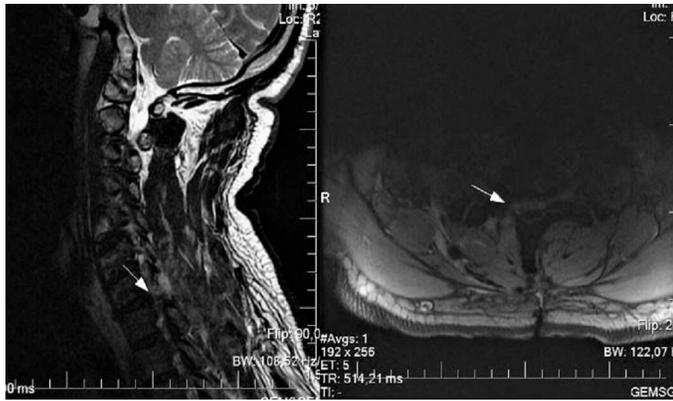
Postoperative cervical MRI displaying nerve root decompression
